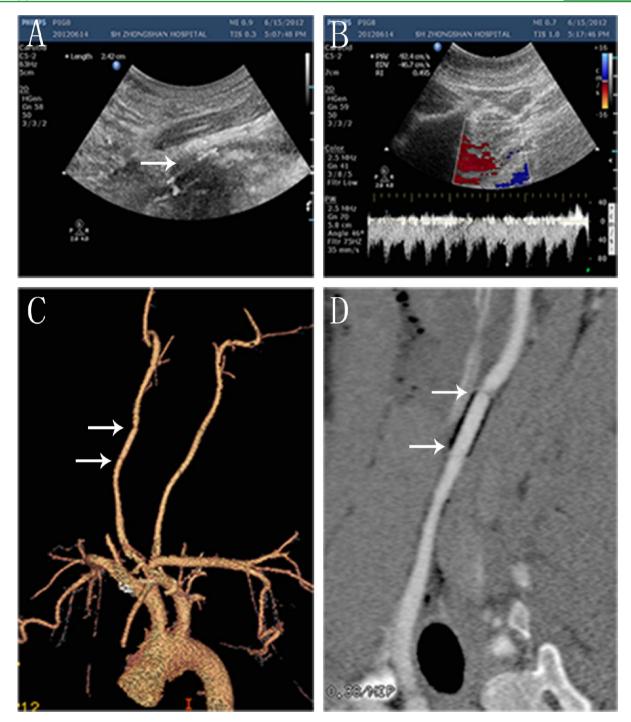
Ultrasonography (A and B) and CT angiography (C and D) examination of implanted ePTFE graft. Red and blue colors in part B indicate the blood flow signals of the implanted synthetic grafts. White arrows indicate the location of the implanted synthetic grafts.
